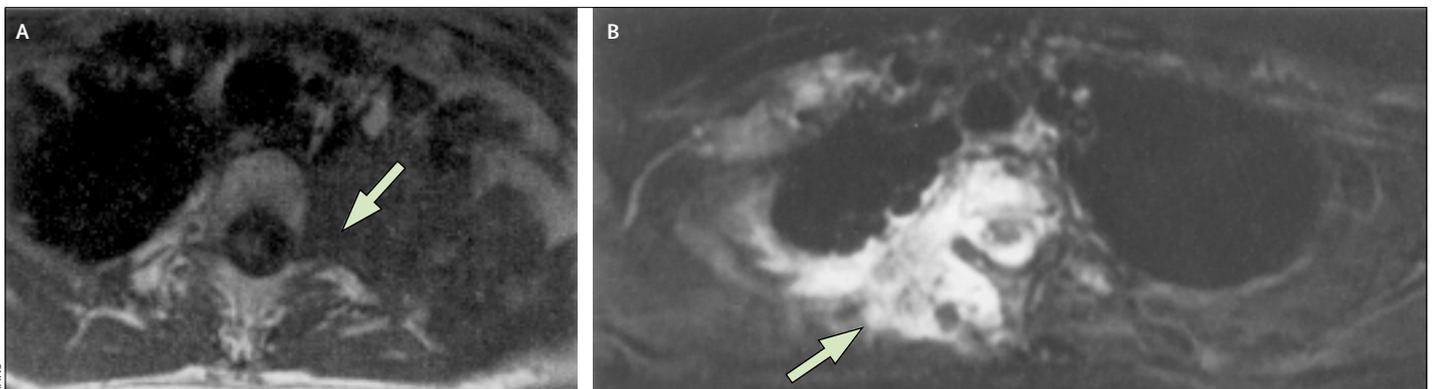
Axial MRI scans of tumours of left (A) and right (B) superior sulci
